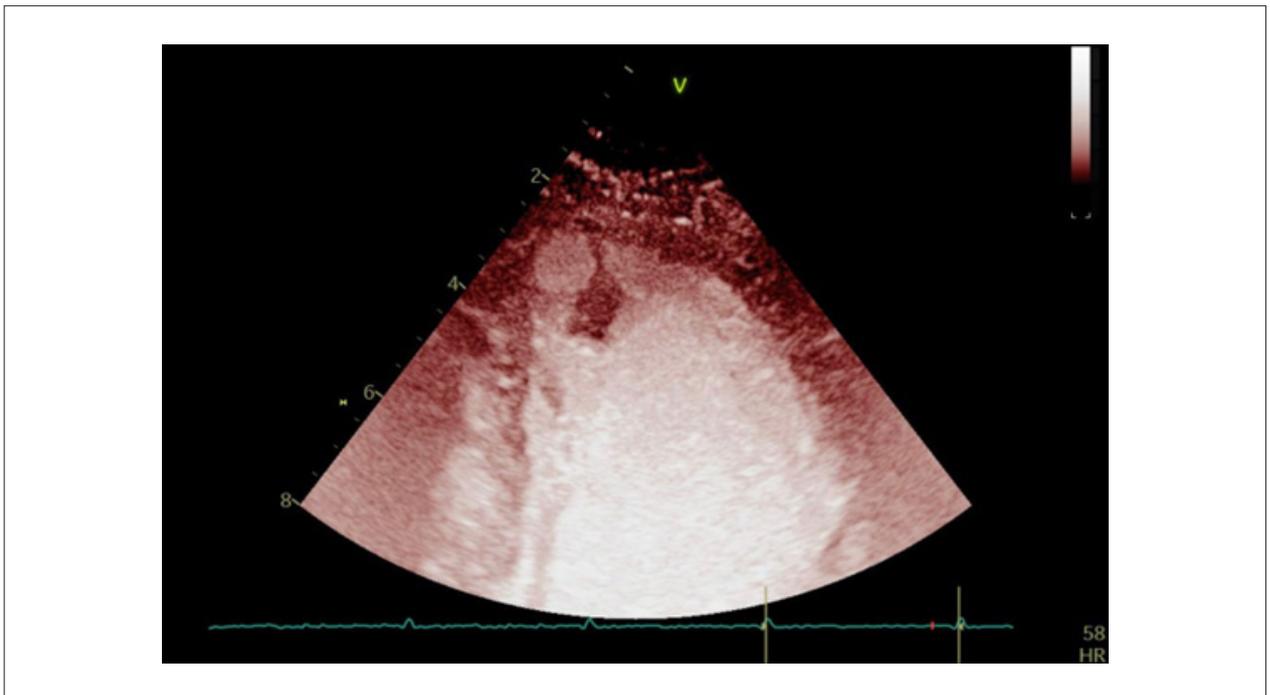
Contrast echocardiogram, showing the presence of a tumor at the apex of the left ventricle, with benign characteristics, suggestive of papillary fibroelastoma.
